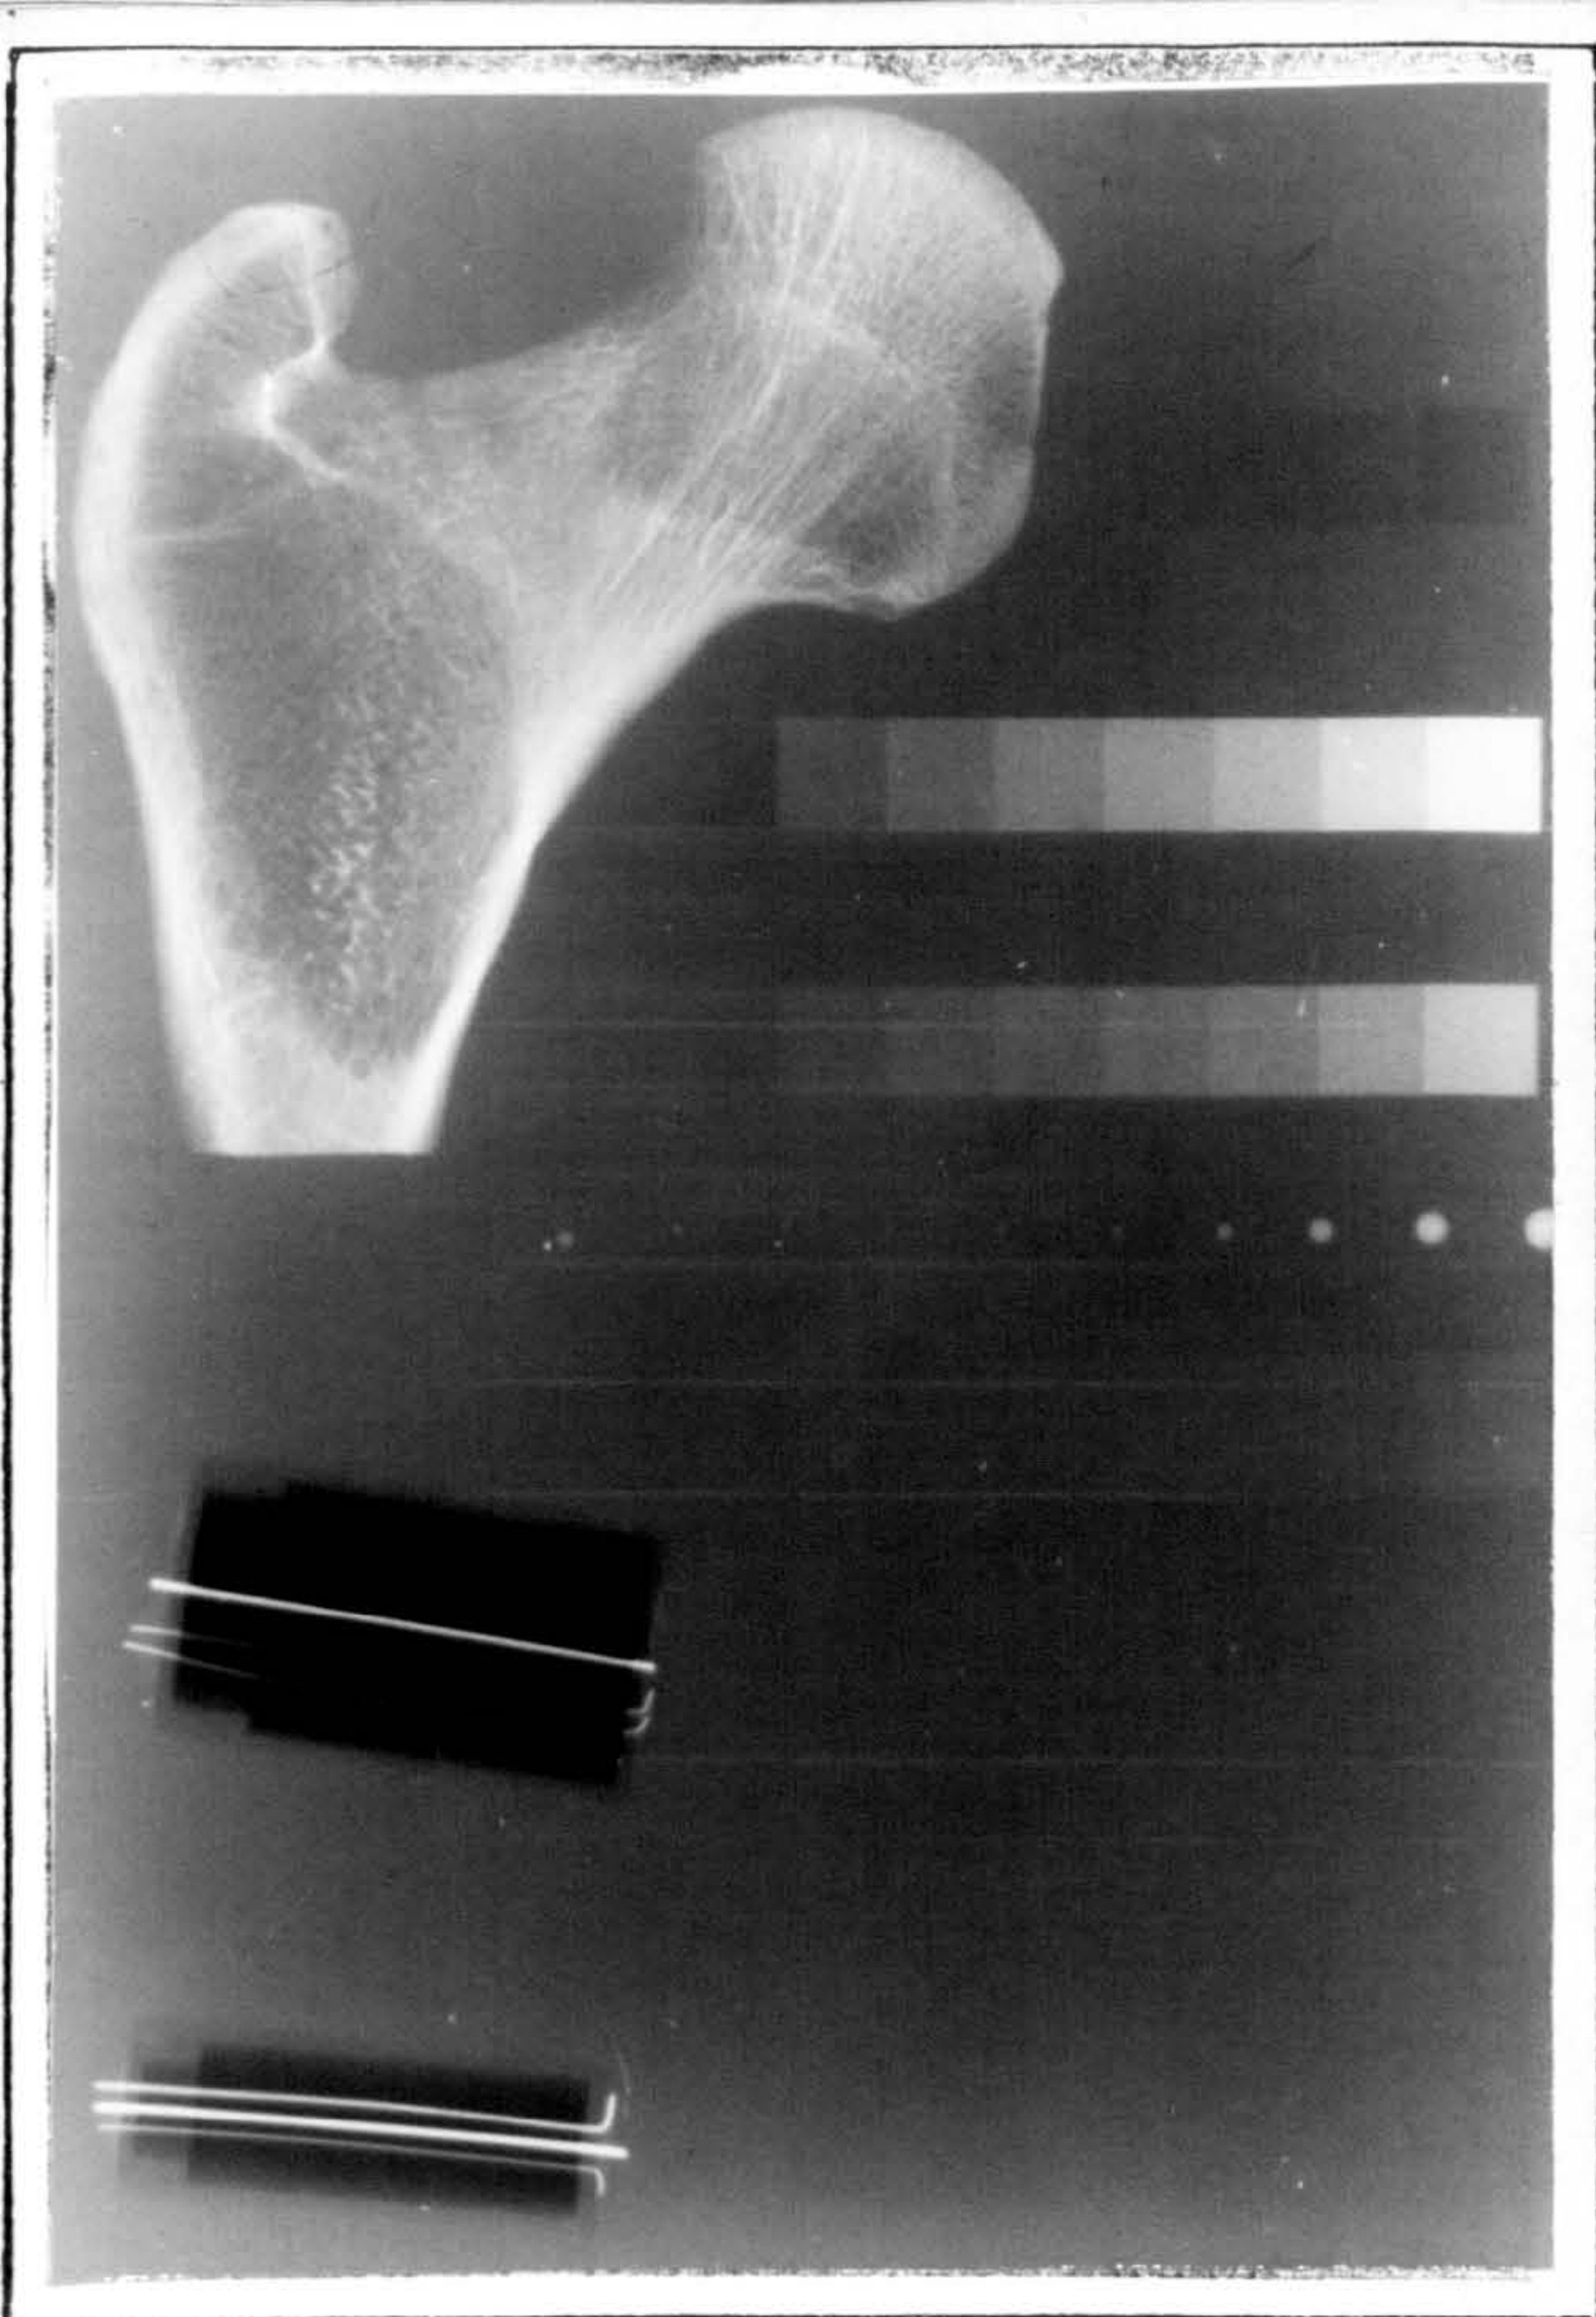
A radiographic test object
